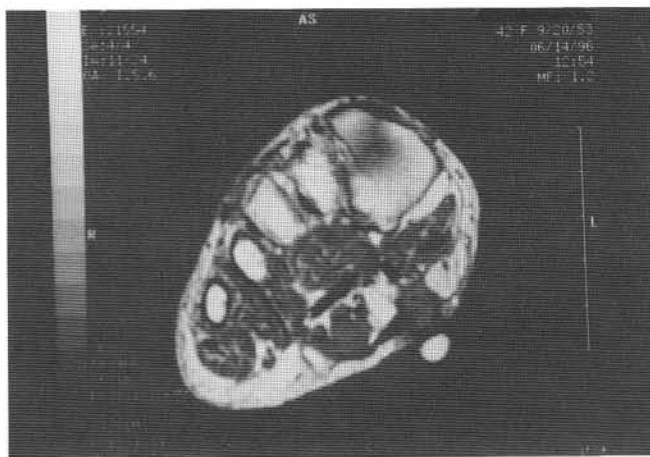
MRI with white capsule demonstrating the location of fibromatosis.
